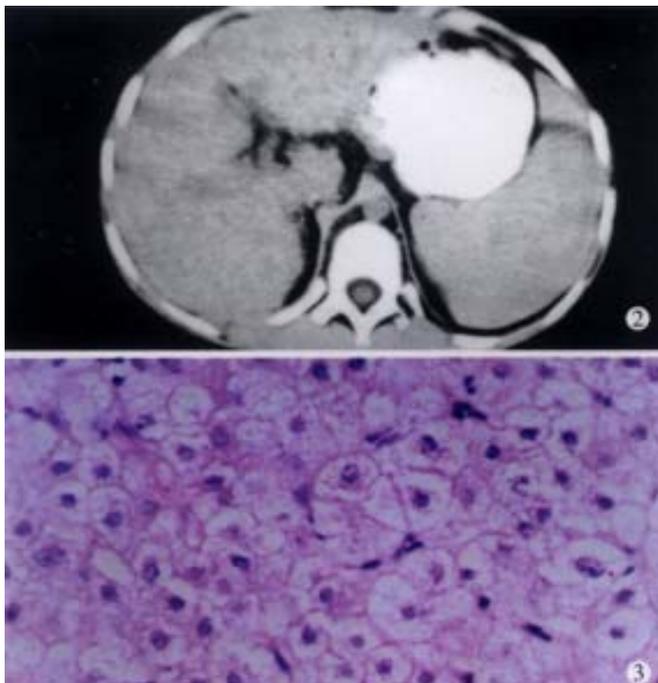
CT picture displays uneven liver density, small nodular changes and splenomegaly extended in an area of eight costae. EM×15000
